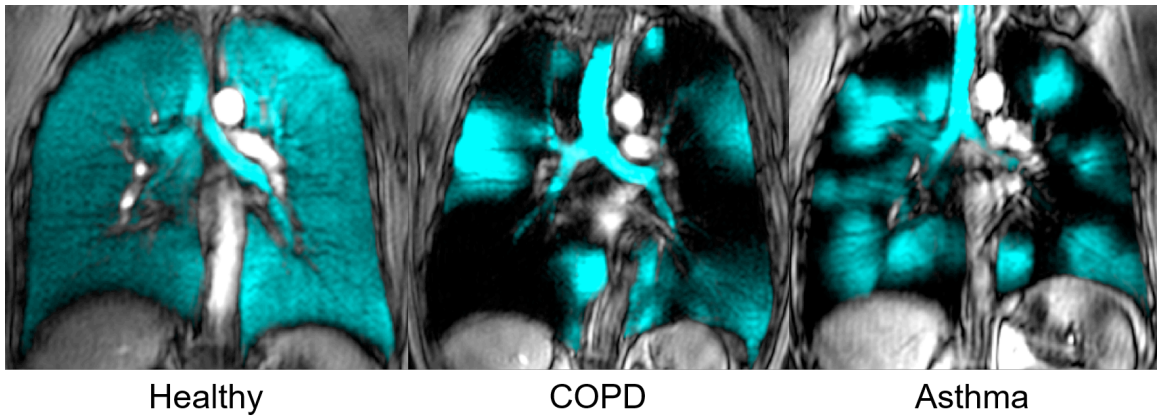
³He Ventilation MRI of COPD and Asthma
